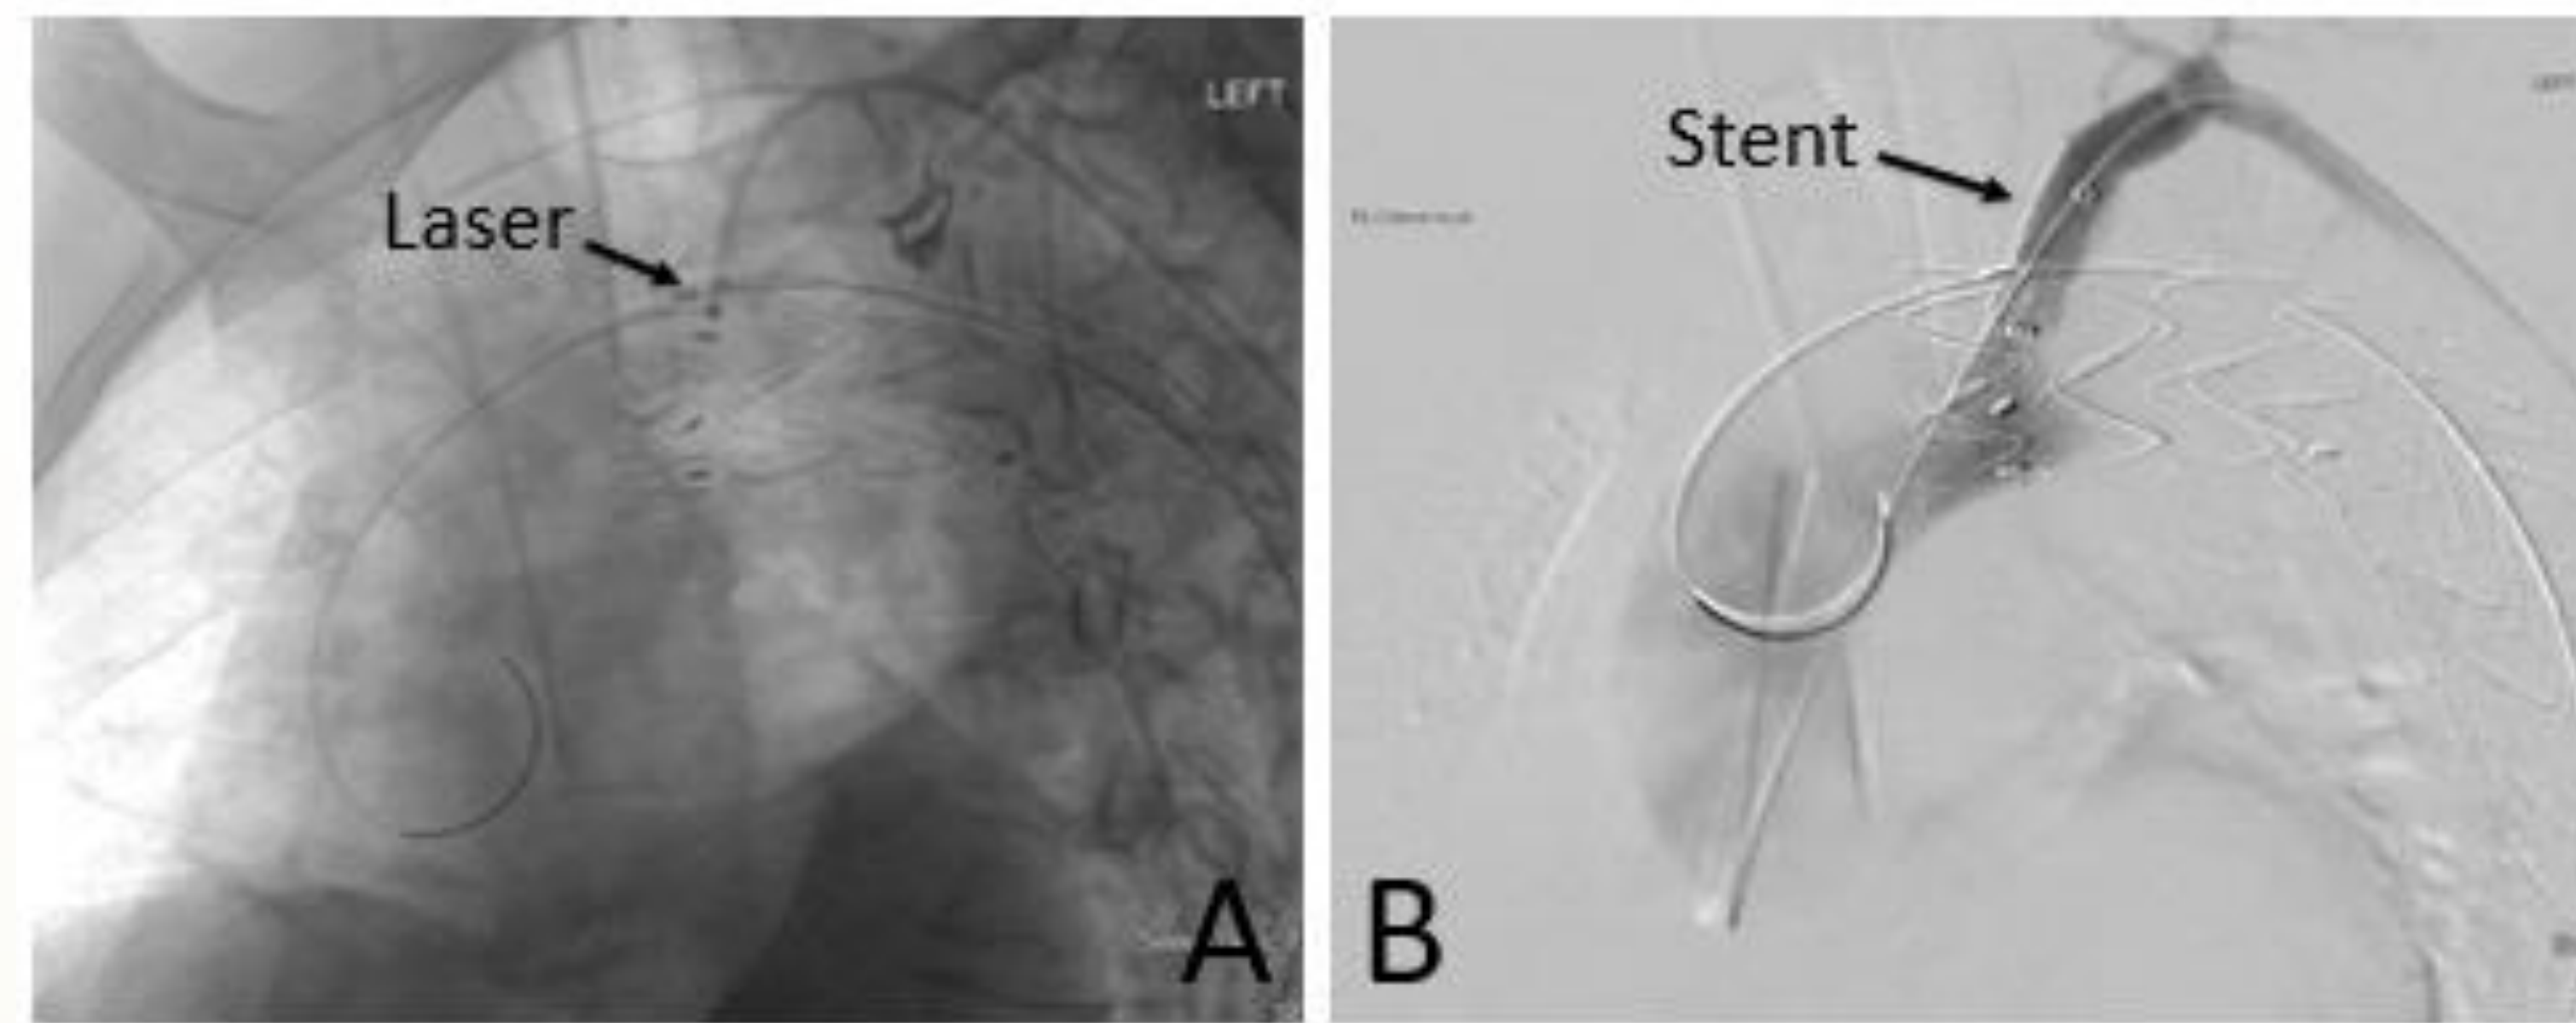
A: The 2.3mm laser fiber is gently advanced to make contact with the endograft, followed by laser energy application for 3 to 5 seconds to create the fenestration. B: The LSA stent is deployed from the brachial access approximately one-quarter into the endograft lumen and three-quarters into the branch vessel. C, D: Left subclavian artery (LSA) stent patency and stable aortic size are demonstrated on 12-month follow-up computed tomography angiography and a volume-rendered image.
